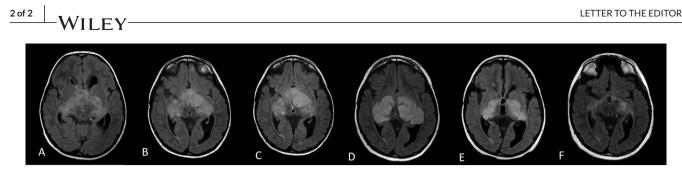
Magnetic resonance imaging (MRI) scan (FLAIR sequence) at the time of diagnosis (A); at completion of 70 weeks of vinblastine (B); 3 months later, before starting dabrafenib (C); at the time of progression, before starting thioguanine, procarbazine, lomustine, and vincristine (TPCV) (D); 6 months after initiation of TPCV (E); 18 months after completion of TPCV (F)
